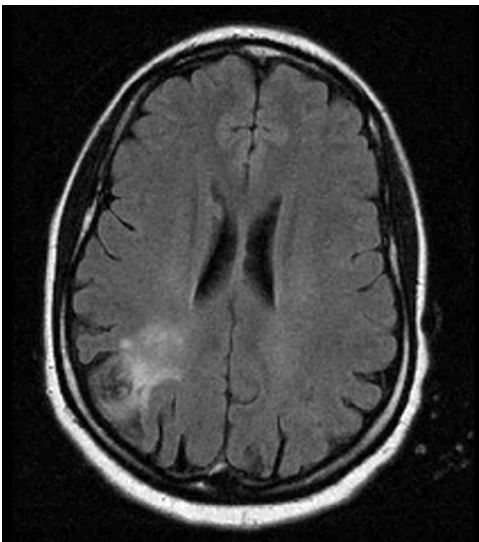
Brain magnetic resonance imaging FLAIR-weighted sequence showing increased signal in the territory of the right middle cerebral artery. Abbreviation: FLAIR, fluid attenuated inversion recovery.
